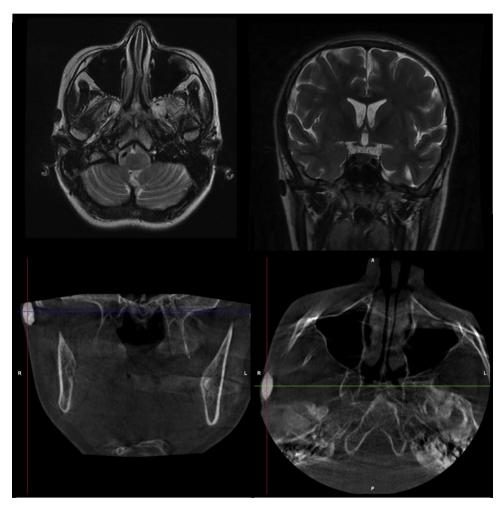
Coronal and axial CBCT views and T1 axial and T2 coronal MRI views of the tumor.
